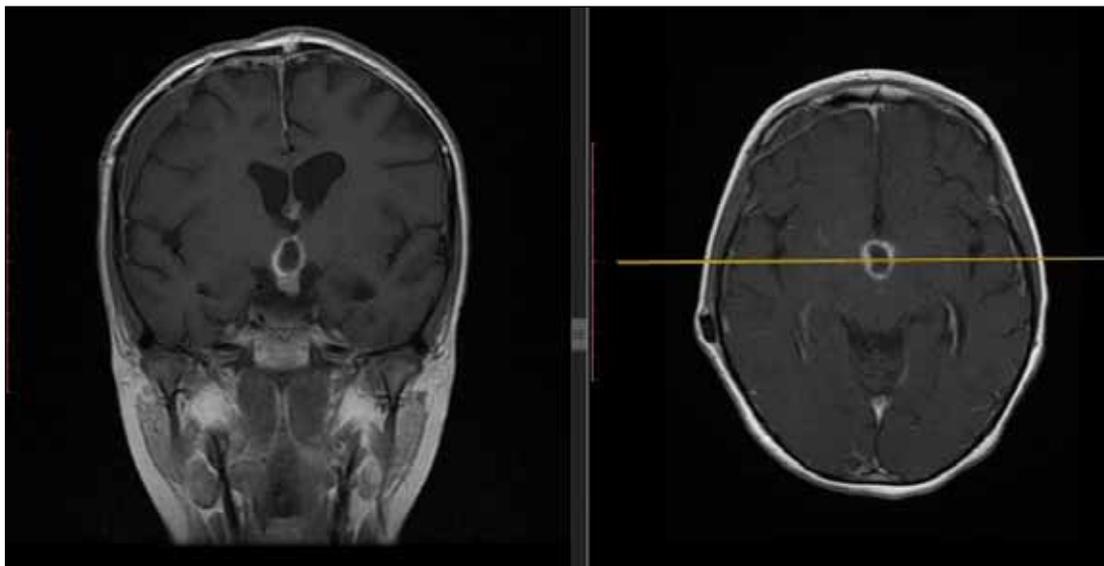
Postoperative first month coronal (left) and axial (right) contrast-enhanced MRI; T1-weighted images with contrast showed postoperative changes.
